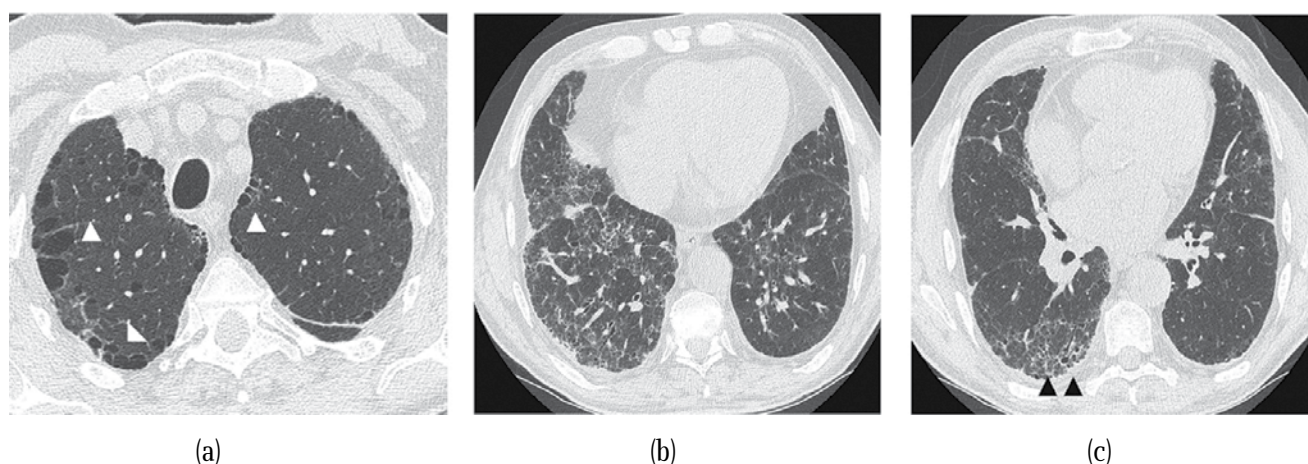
HRCT toraksi e pacientit të figurës 1.
